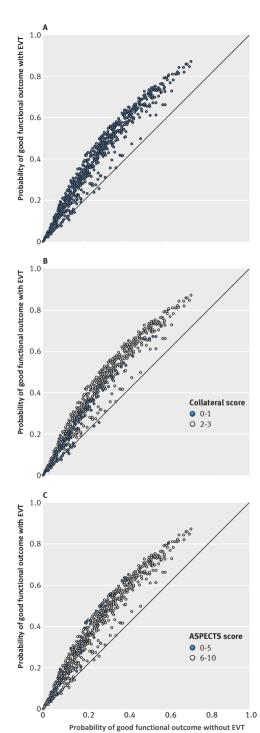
(A) Predicted probabilities of good functional outcome (modified Rankin Scale (mRS) score 0-2) for all individual patients in combined derivation and validation cohort (n=760). Each dot represents one individual patient, with the probability of good functional outcome (mRS score 0-2) without endovascular treatment (EVT) expressed on x-axis, and probability for good functional outcome with EVT on y-axis. Above the diagonal line the predicted probability of good functional outcome with EVT is higher than that without EVT. The farther above this line, the larger the predicted effect of treatment. (B) Patients highlighted with no or poor collaterals (score 0-1). (C) Patients highlighted with low Alberta Stroke Program Early CT Score (ASPECTS, score 0-5).
